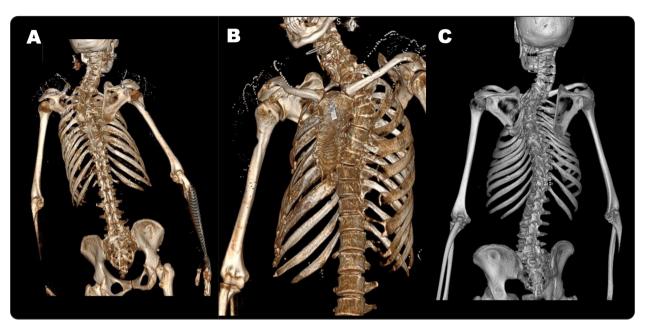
(A) CT 3D view showing kyphoscoliosis. (B) CT 3D view kyphoscoliosis lateral view (C) Kyphoscoliosis posterior veiw
